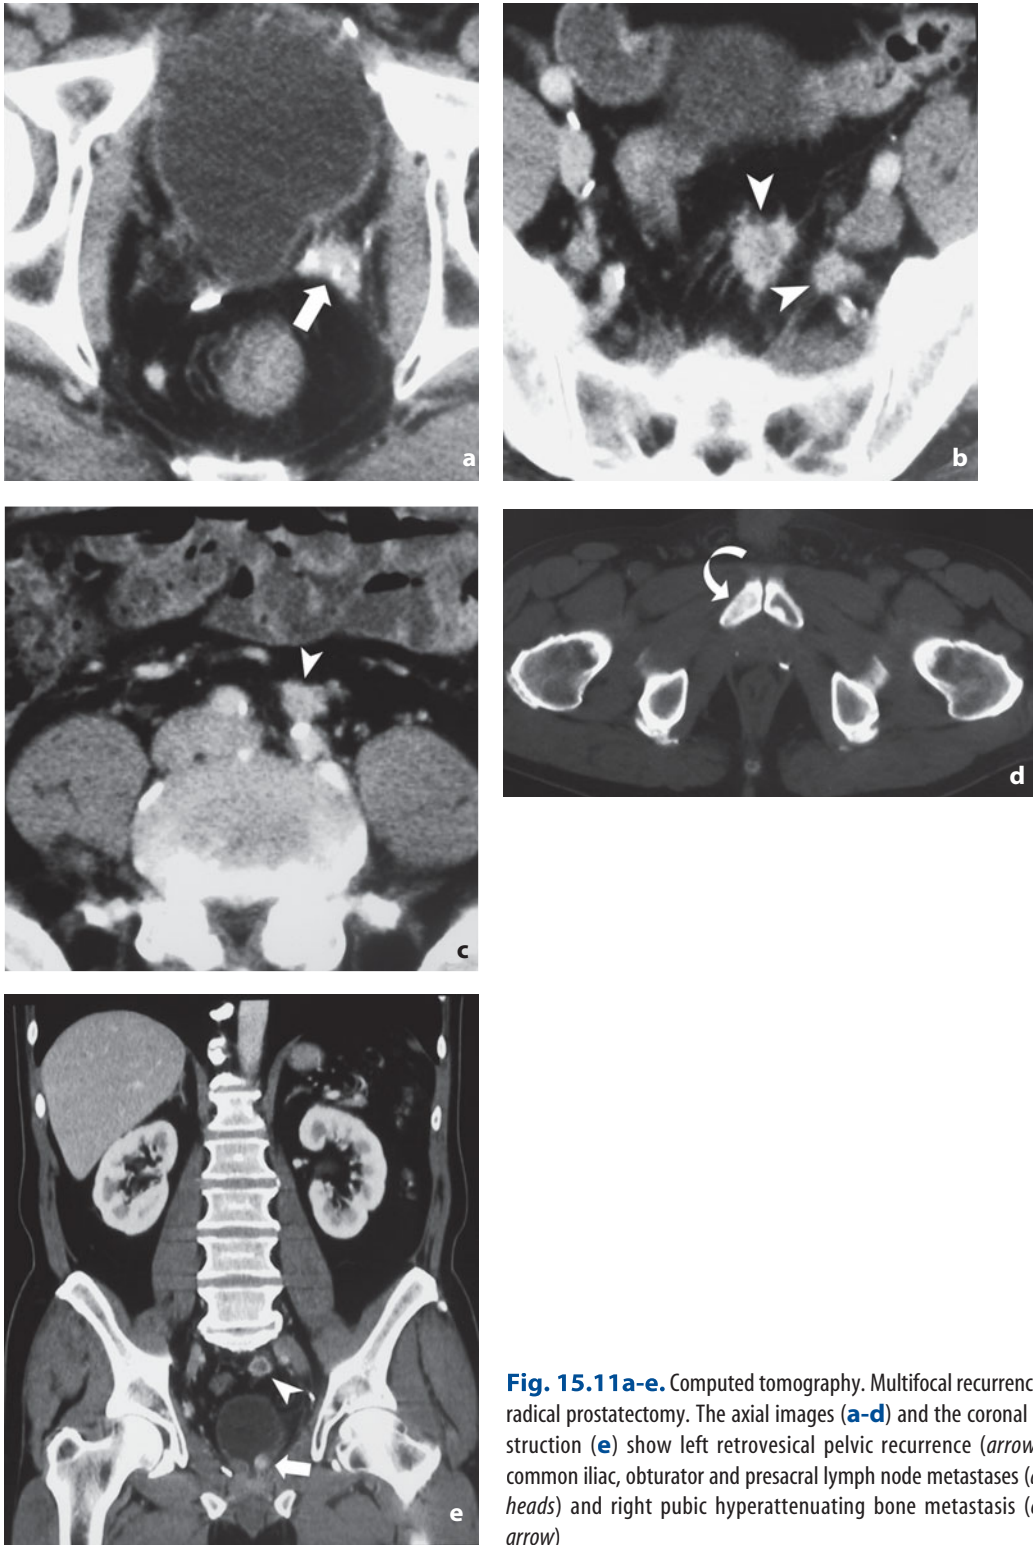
Computed tomography. Multifocal recurrence after radical prostatectomy. The axial images (a-d) and the coronal reconstruction (e) show left retrovesical pelvic recurrence (arrow), left common iliac, obturator and presacral lymph node metastases (arrowheads) and right pubic hyperattenuating bone metastasis (curved arrow)
